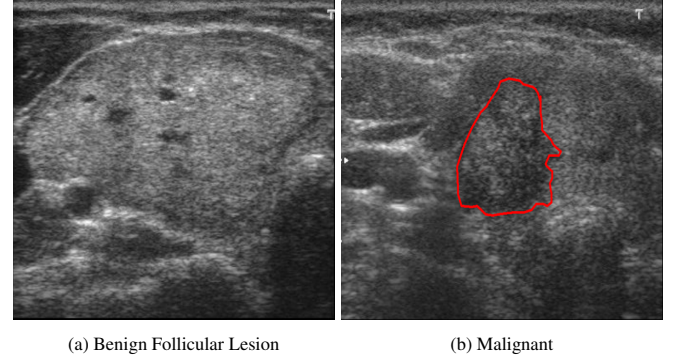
Ultrasound images of (a) Benign and (b) Malignant Thyroid Lesions with the Regions of Interest (ROI) in red.
